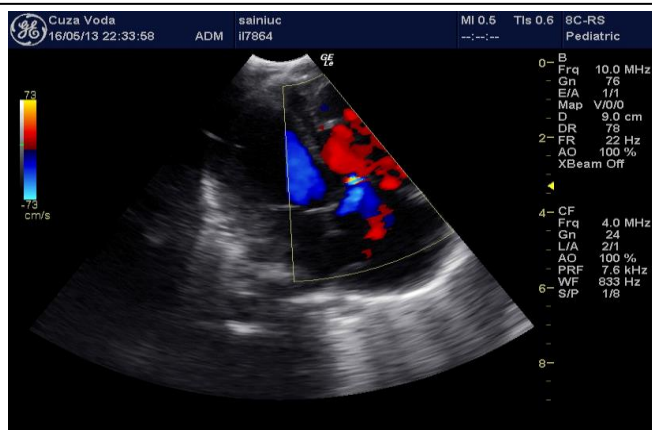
Doppler echocardiography in the newborn.
